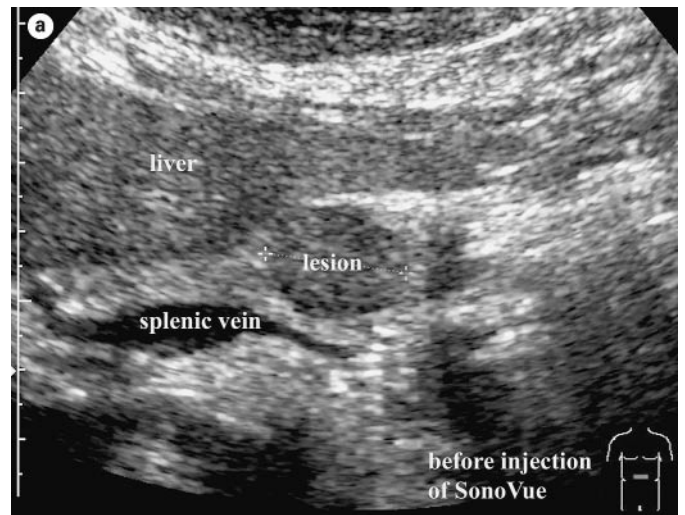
Pancreatic metastasis of a renal cell carcinoma at conventional (a) and echo-enhanced sonography (b). a Low-echo mass with sharply delineated margins without dilatation of Wirsung's duct. b Highly vascularized lesion.
